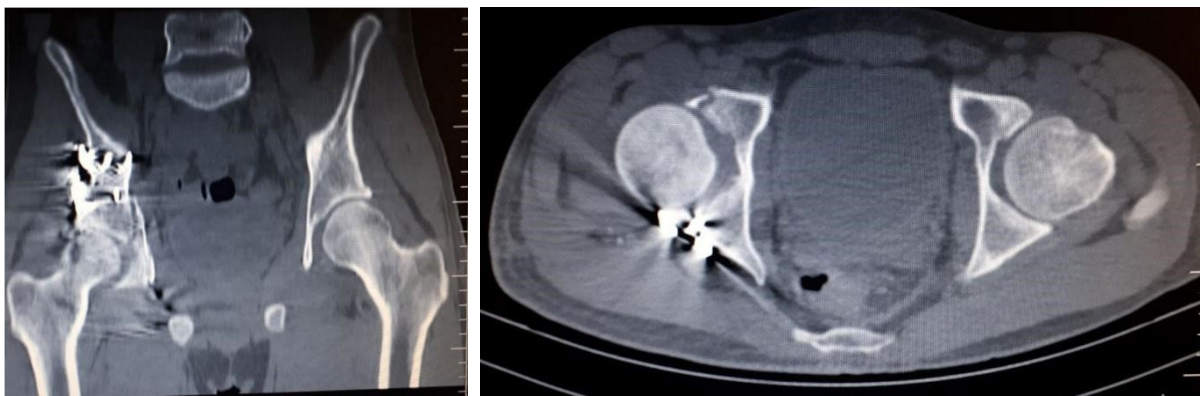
Post-operative coronal and axial CT showing acceptable reduction and removal of the intra-articular fragments
